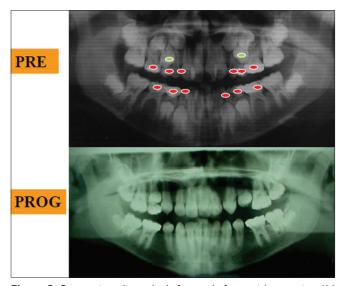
Panoramic radiographs before and after serial extraction (14 teeth were extracted, 12 deciduous - red circle- and 2 permanent upper first premolars - green circle)
